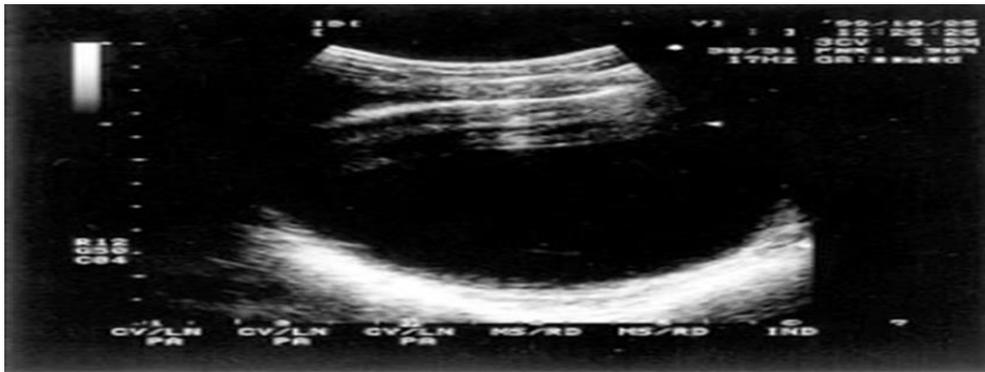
The uterus was not detected on ultrasound.
